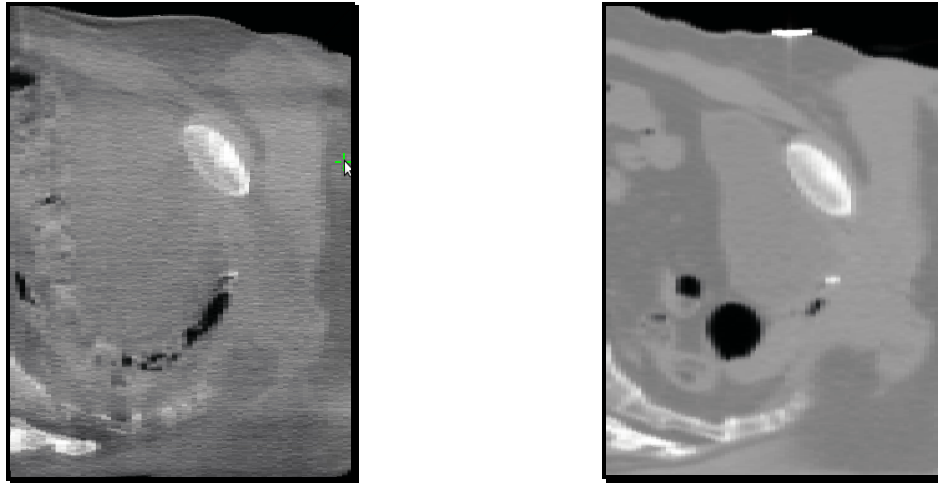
Sagittal slice from the CBCT image taken before treatment (left) and the CT image used for planning (right). The difference in bladder filling is approximately three cm.
